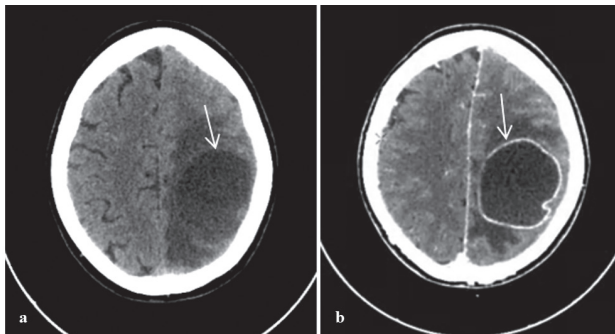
Axial CT pre (a) and post (b) intravenous contrast shows a ring enhancing brain lesion (arrow) located in the left parietal lobe with surrounding edema.
